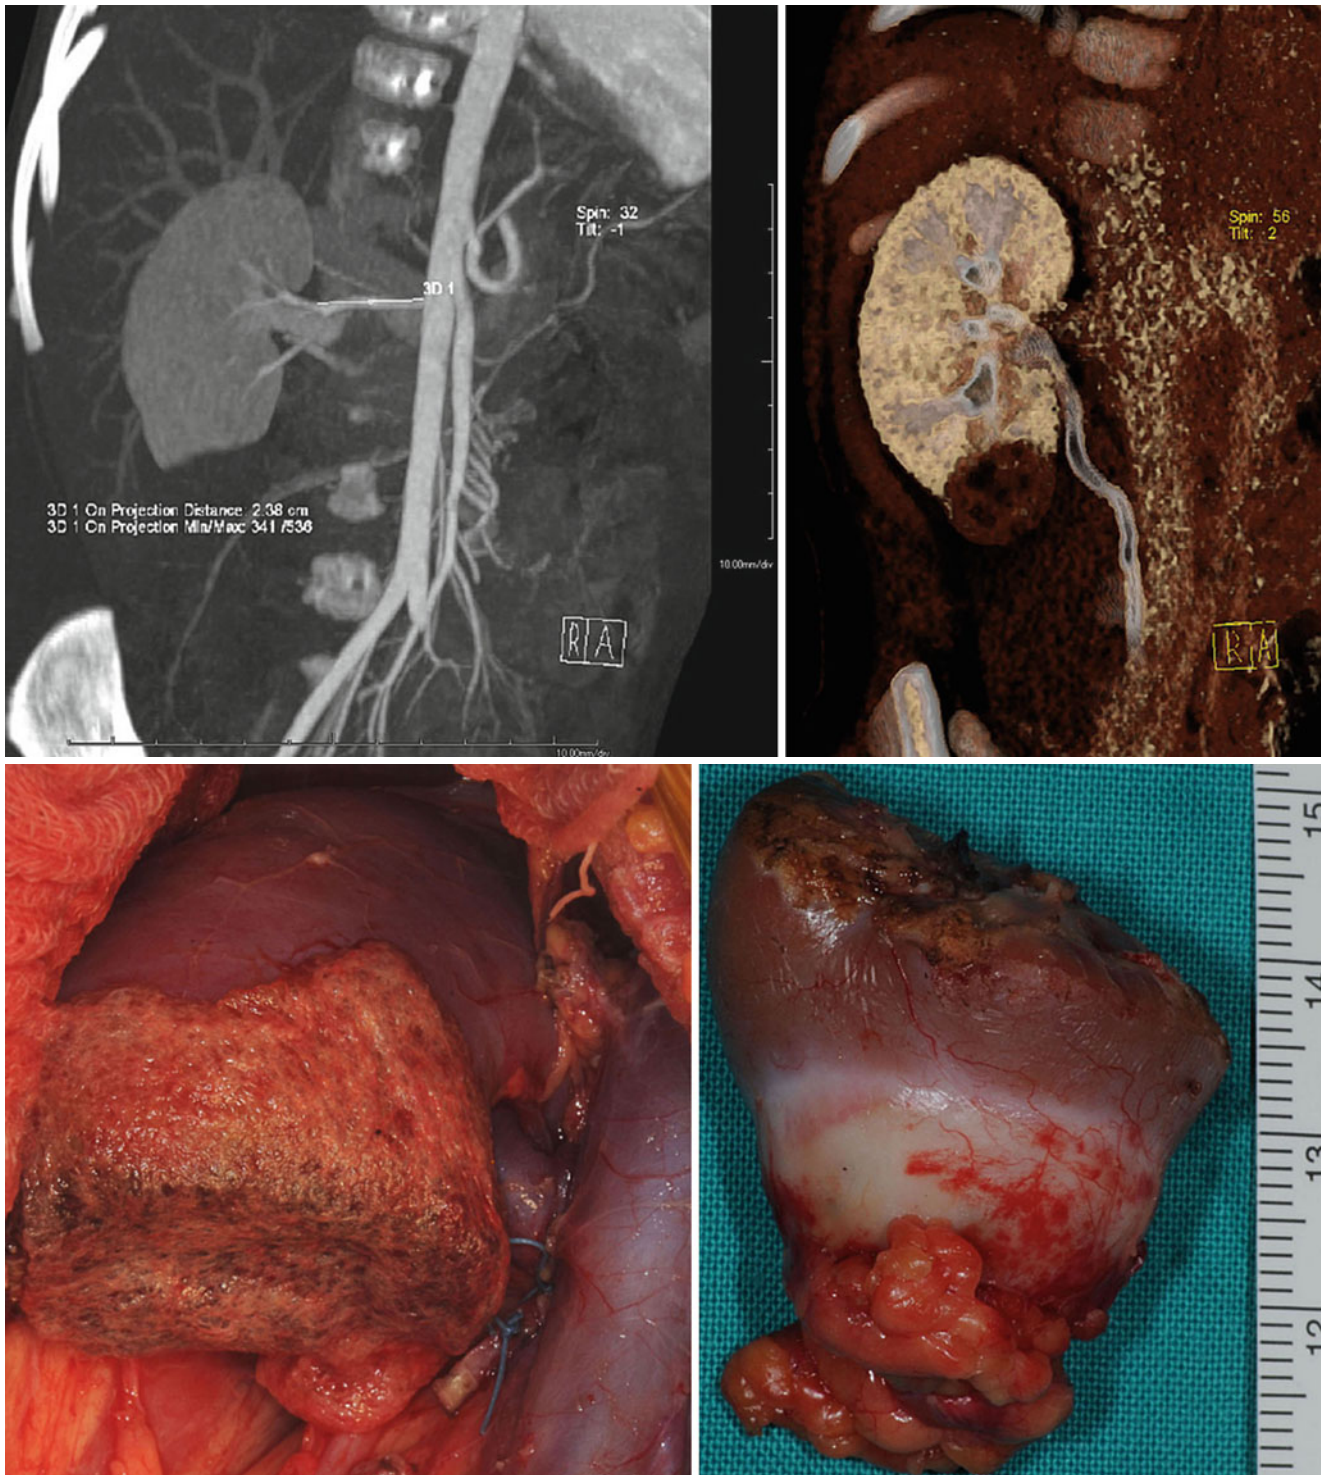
Preoperative, 3-D helical CT coronal views of a small WT sited in the lower pole of the right kidney (*top row*). Intraoperative view of the kidney remnant after partial nephrectomy, and gross appearance
